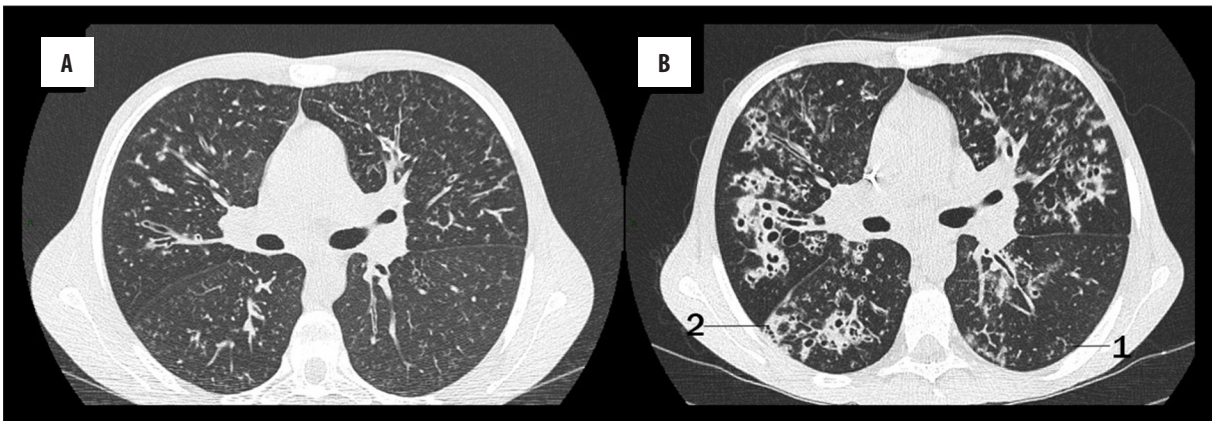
Significant deterioration of the HRCT images observed during exacerbation. The interval between examination (A) and (B) was two months. In addition to worsening of bronchiectasis and airway wall thickening, the image (B) showed substantial progression of mucus plugging, which in the smaller peripheral airways is observed as the “tree-in-bud” sign (1). It represents dilated and mucus-filled centrilobular bronchioles. On image B also small consolidation regions can be observed (2).
